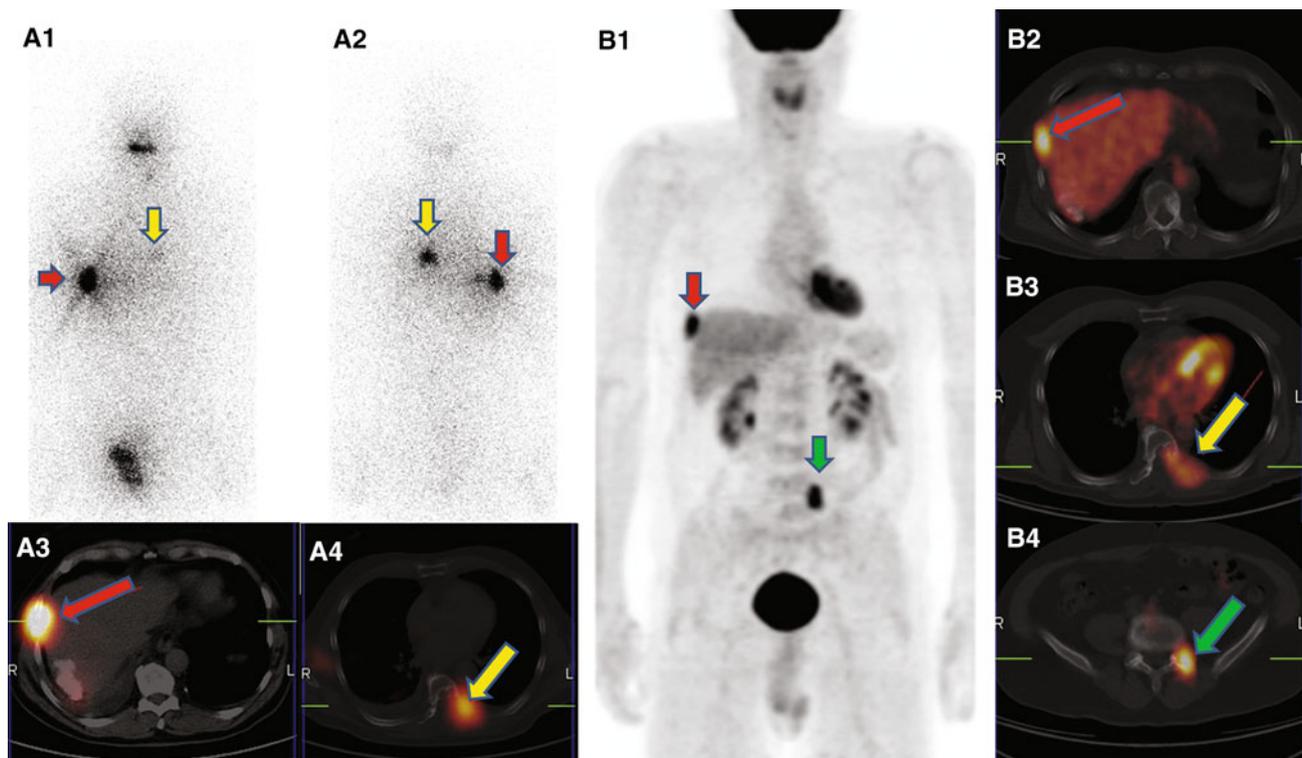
PTWBS in anterior (a1) and posterior (a2) view, axial ^{131}I SPECT/CT (a3, a4), ^{18}F FDG PET (b1) and axial ^{18}F FDG PET/CT (b2–b4) images in a 65-year-old male patient with increased Tg levels after thyroidectomy for a DTC. PTWBS detected increased ^{131}I
